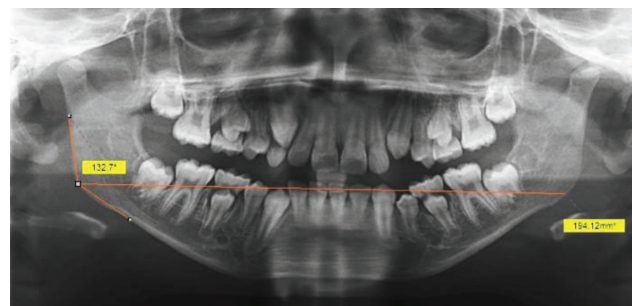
Measurements of mandibular gonial angle and bigonial width on panoramic radiograph
